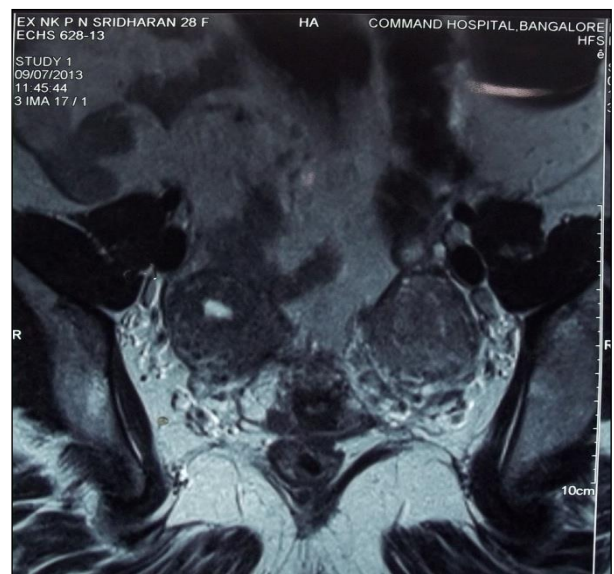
MRI image of pelvis (post MTP) confirming Partial Bicornuate uterus.
